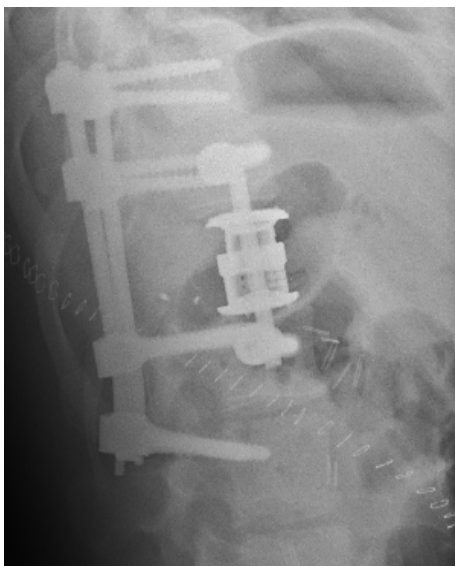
Xrays following 'en bloc' excision of tumour in figure 1
